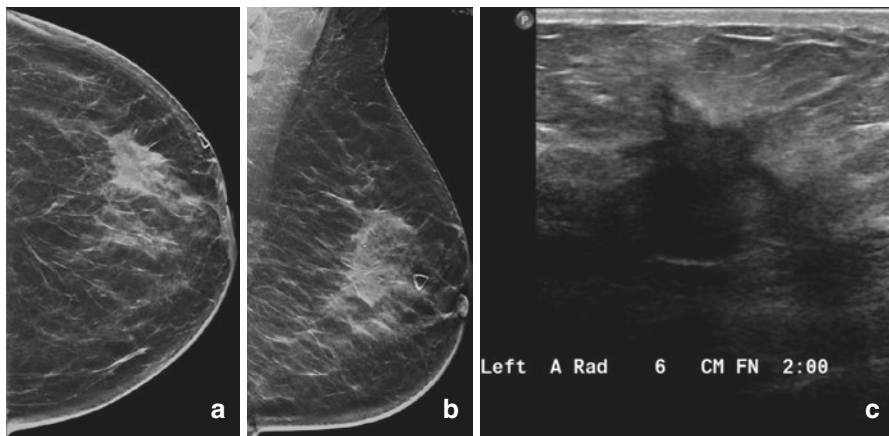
Mammogram. (a) Left CC view. (b) Left MLO view. (c) Targeted left breast ultrasound
